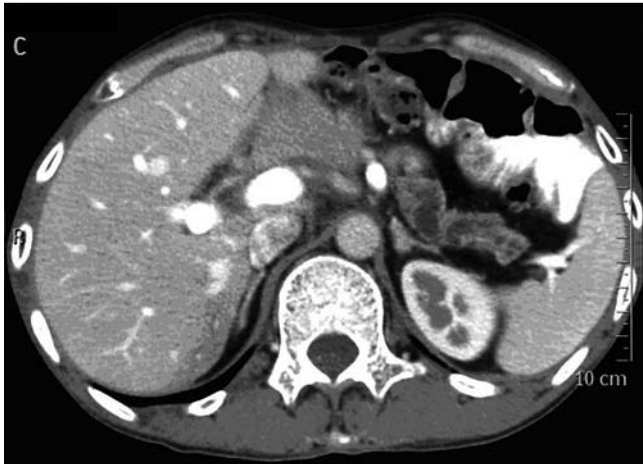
Computed tomography (CT) image showing the severely dilated pancreatic duct before the endoscopic ultrasound (EUS)-guided pancreatic duct drainage.
